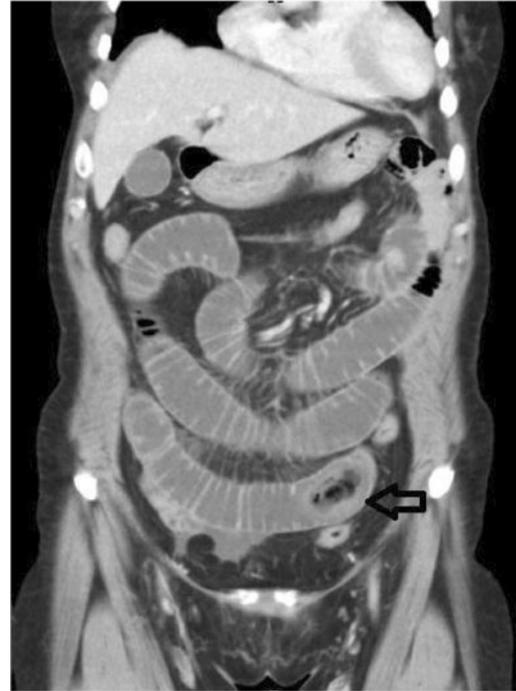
Coronary view of abdominal CT scan. Black arrow shows the foreign body in the small bowel cavity.
